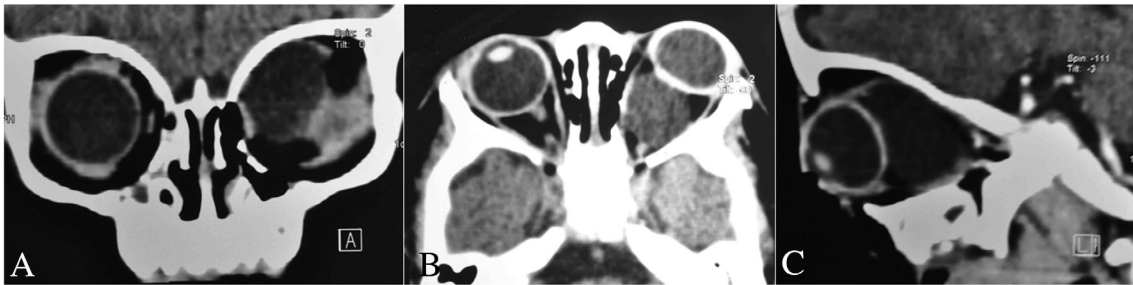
CT Scan images showing a well-defined isodense, intraconal, cystic lesion located in the superomedial orbit with the extraocular muscles being distinctly identified separately from the cyst. (A – coronal, B – axial and C – sagittal slices).
